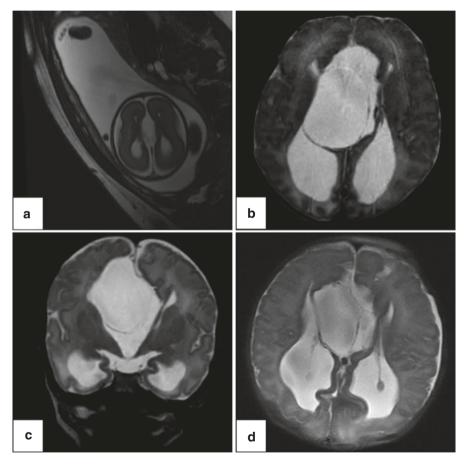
MRI, T2 weighted images, demonstrate a neonate with agenesis of the corpus callosum and multiloculated hydrocephalus before and after surgery. (a) A prenatal MRI demonstrates a midline cyst, colpocephalic lateral ventricles, and agenesis of the corpus callosum. (b, c) Preoperative MRI images in the axial and coronal plane, respectively, demonstrate two midline cysts. (d) Surgery consisted of fenestration of the midline cysts into the posterior horn of the right lateral ventricle. Imaging on postoperative day 1 demonstrates reduction in volume of the lateral ventricles and the midline cysts
